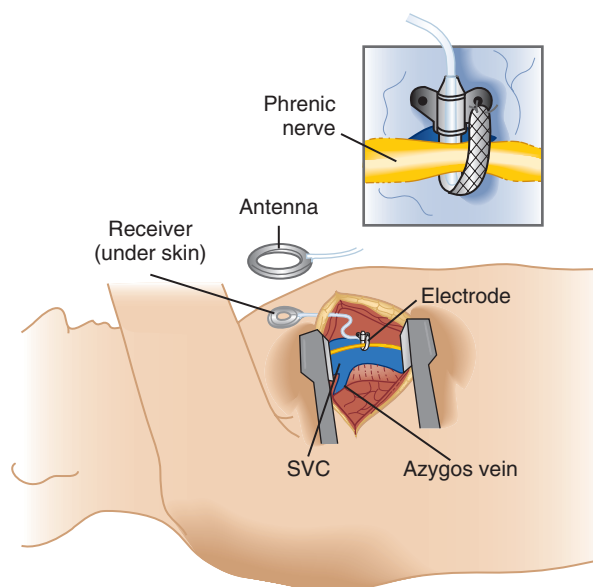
■ Placement of phrenic nerve pacing lead to an intralateral thoracotomy. SVC, Superior vena cava. (From Kanaan S, Ducko CT: Disorders of ventilation: diaphragmatic pacing. In Fauci AS, et al, eds: *Harrison's principles of internal medicine*, ed 17, online update, New York, 2008, McGraw-Hill.)
